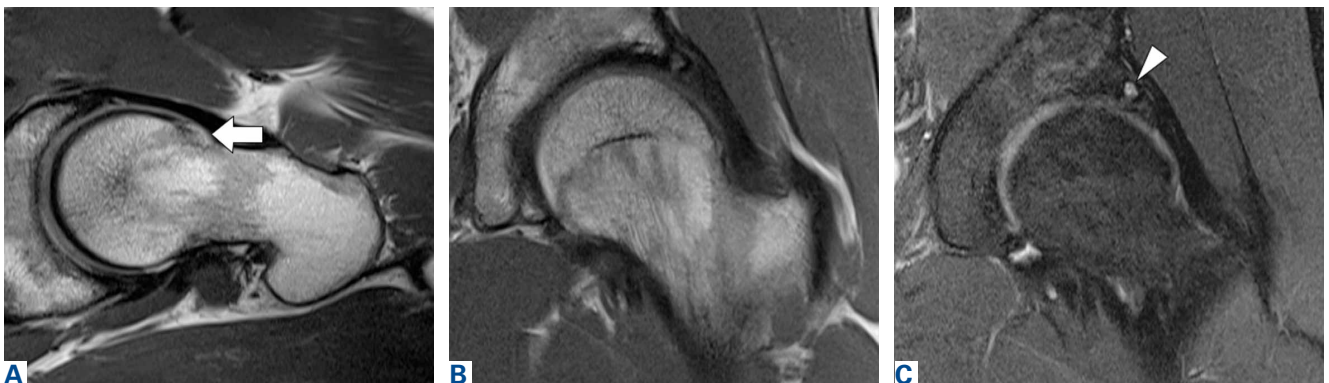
Combination cam-pincer deformity. (A) T2-weighted axial-oblique magnetic resonance imaging (MRI) shows convexity of anterolateral femoral head-neck junction (arrow) with decreased offset and widened femoral neck. (B) T1-weighted coronal MRI shows acetabular overcoverage. (C) Fluid-sensitive MRI shows osseous response to femoroacetabular impingement (arrowhead).
